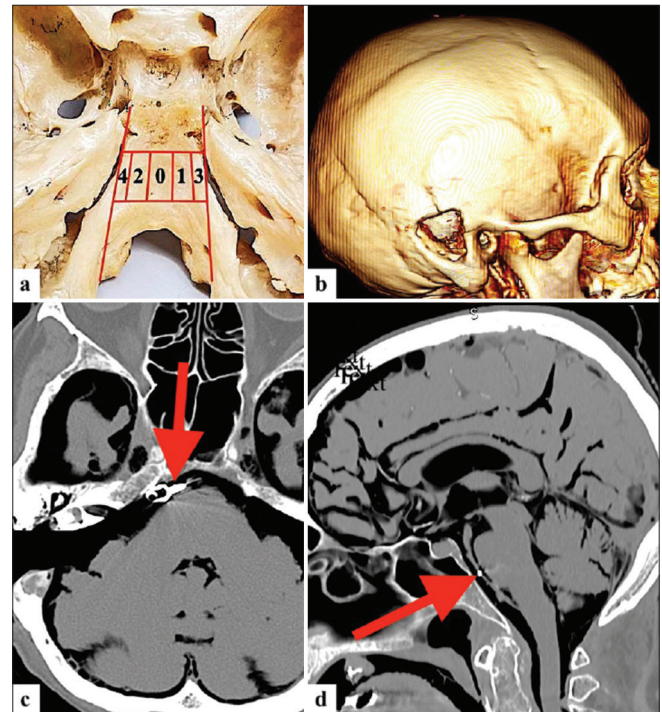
(a) Depiction of the clival zone II with the longitudinal classification of the basilar artery (BA) position in relation to the midline. The red bar indicates the BA position within clival zone, which extends from the internal auditory canal (IAC) to the jugular tubercle into: grade-0, midline; grade-1, right paramedian; grade-2; left paramedian; grade-3, right petro-clival junction, and grade-4, left petro-clival junction. (b-d) Post-procedural cranial computed tomography scans showing the anterior inferior cerebellar artery (AICA) clipping using the presigmoid retrolabyrinthine suprameatal approach (PRSA) approach. (b) 3D reconstruction of right side PRSA craniotomy, (c) axial, and (d) sagittal sections showing the final position of the aneurysmal clip (red arrow) on the AICA origin from BA.
